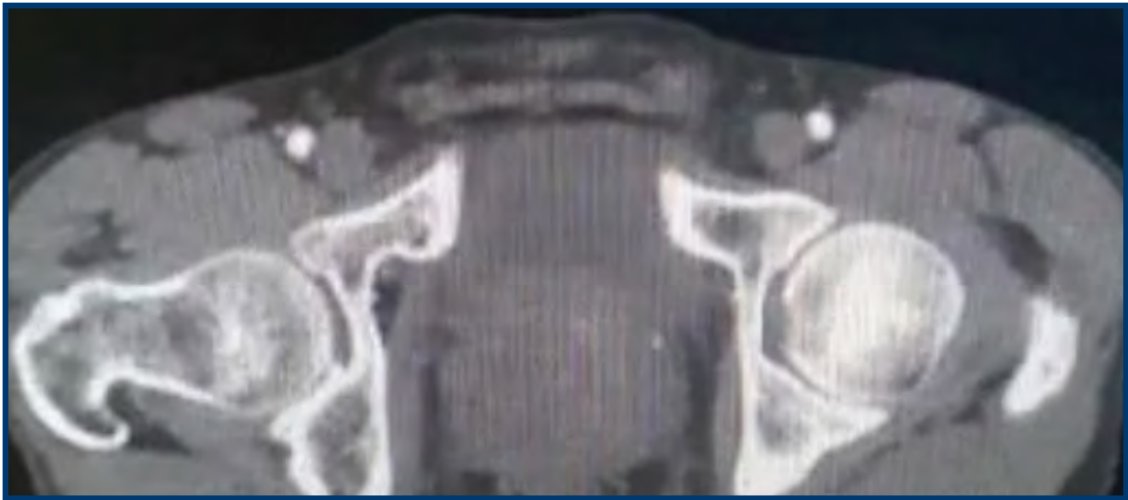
Lower limb-computed tomography angiography. No macroscopic vascular lesions were detected.
